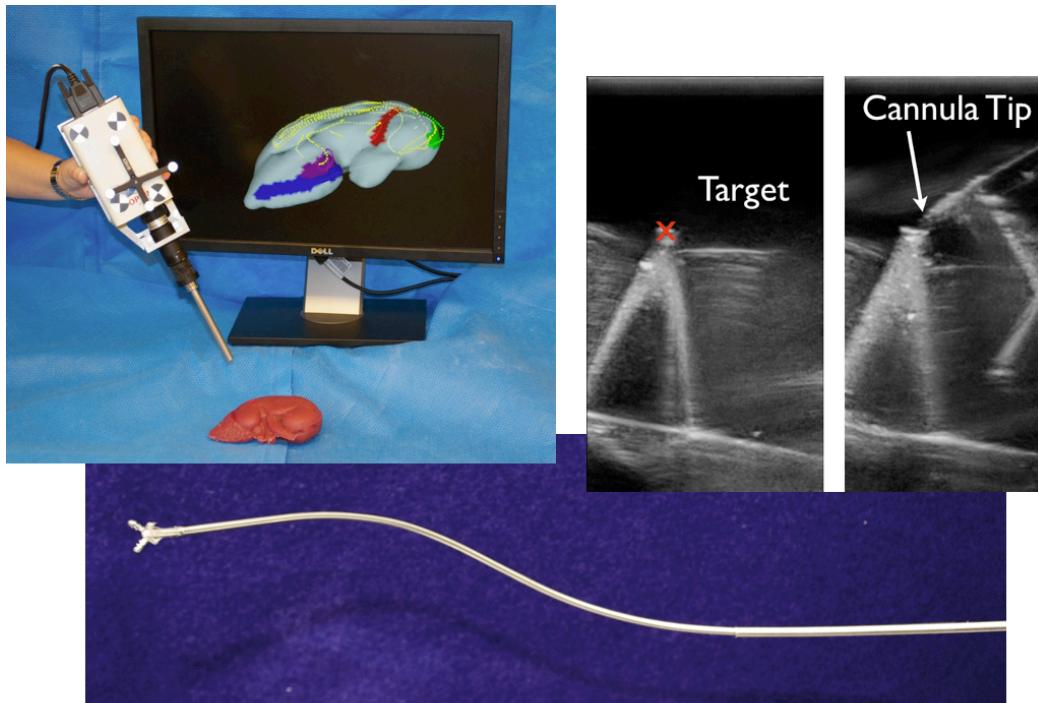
Image-Guided Targeting of Concentric Tube Robots: Experiments using Ultrasound, Computed Tomography, and Magnetic Resonance Imaging
